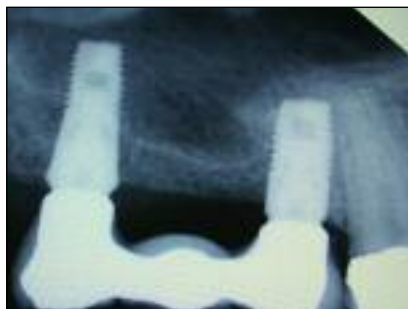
The bridge attached with temporary restorative material covering the screw heads. Figure 10: An anteroposterior radiograph was taken of the implants at fit stage and the occlusion examined and adjusted using Schimstock as the indicator.
